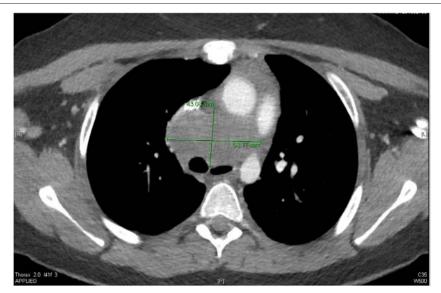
Contrast-enhanced computed tomography axial view at T4 level demonstrating large mediastinal nodal mass necessitating urgent radiation therapy.
